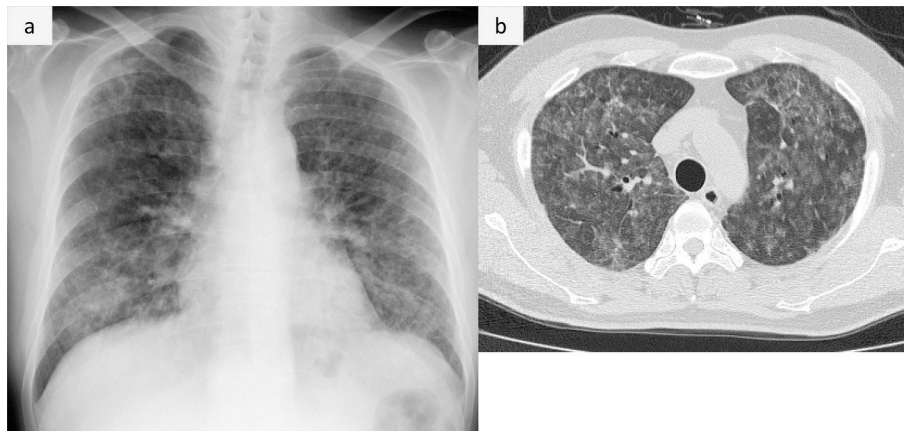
(a) Chest X-ray and (b) chest CT show bilateral diffuse ground-glass opacities and infiltration shadows.
